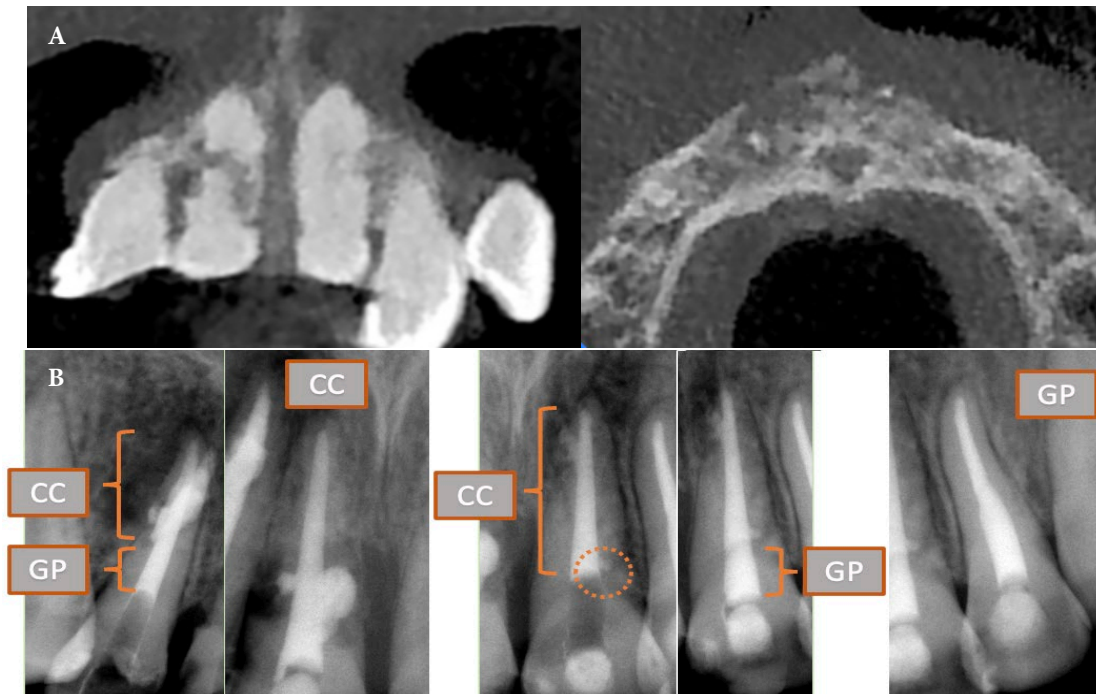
A) Arrest of inflammatory process and healing of the periapical lesion on axial and coronal CBCT views; B) Obturation with CEM Cement(CC) and gutta percha (GP)
